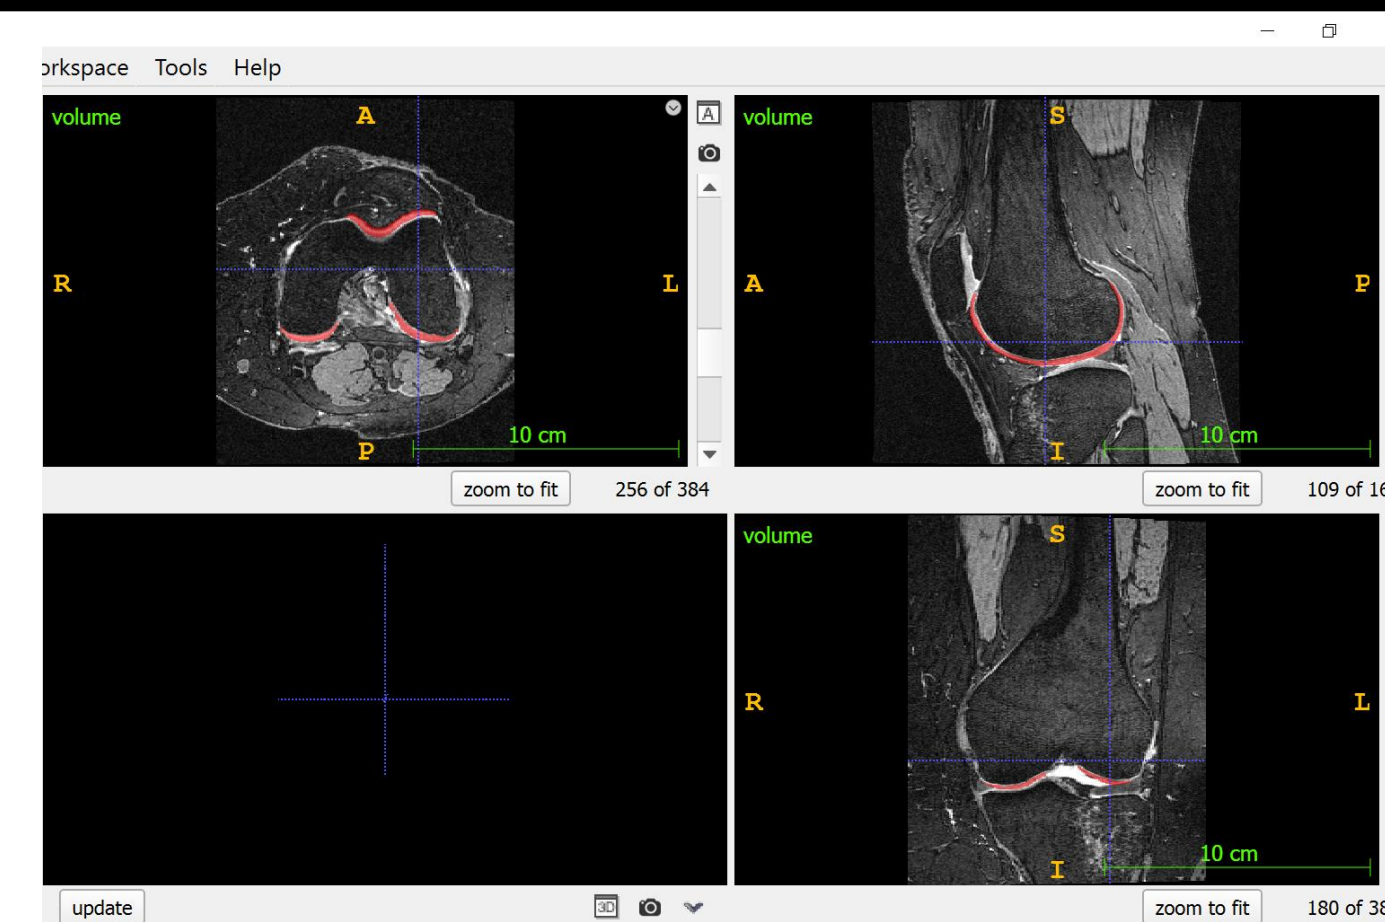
MRI cartilage volume automated segmentation utilizing IWOAI challenge algorithm.
